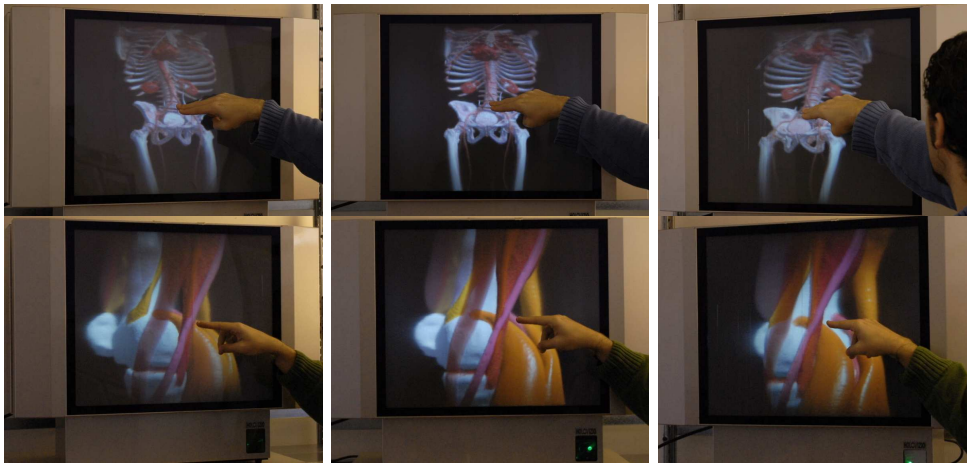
Inspecting raw and segmented datasets on the light field display. Top: Raw whole body contrast CTA acquired on a 16 detector CT scanner (source: Radiology Department, University of Geneva). The volume has a resolution of  $512 \times 512 \times 1559$  with 16 bit/sample. Bottom: segmented leg reconstructed from MRI acquisitions (source: MiraLab, Geneva). The volume has a resolution of  $404 \times 474 \times 2050$ . Pictures are taken with a hand-held camera at different viewing angles, in order to highlight the horizontal parallax of the light field display. Images are rendered at about 6.5fps.
